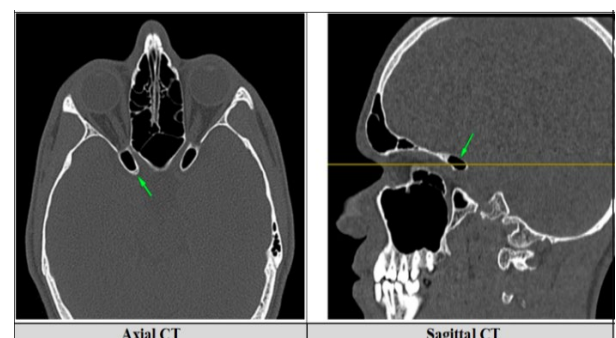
Axial and sagittal CT demonstrating bilateral anterior clinoid process pneumatization. *Green arrow (pneumatized clinoid process); horizontal yellow line (axial/sagittal cross-reference line).
